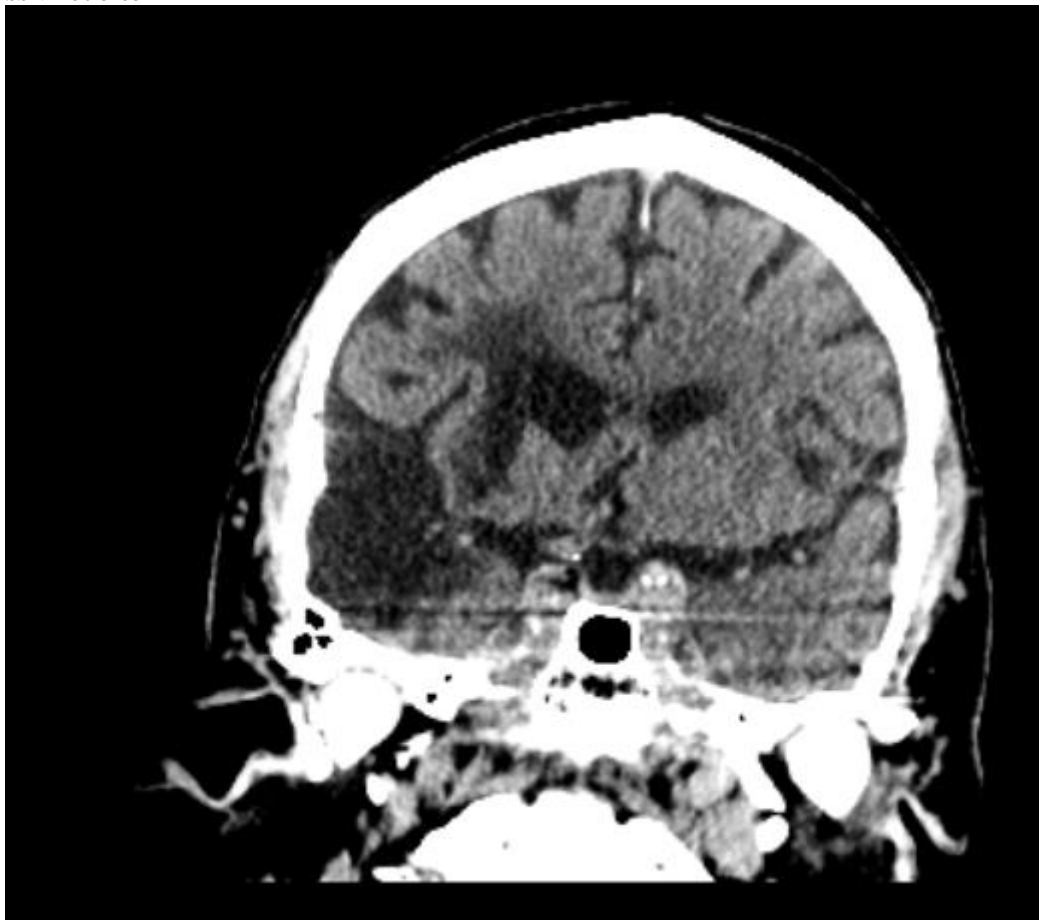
CT head: A small area of cortical low density shown in the left inferolateral frontal lobe just above the level of the frontal operculum. This is suggestive of an evolving cortical infarct.
